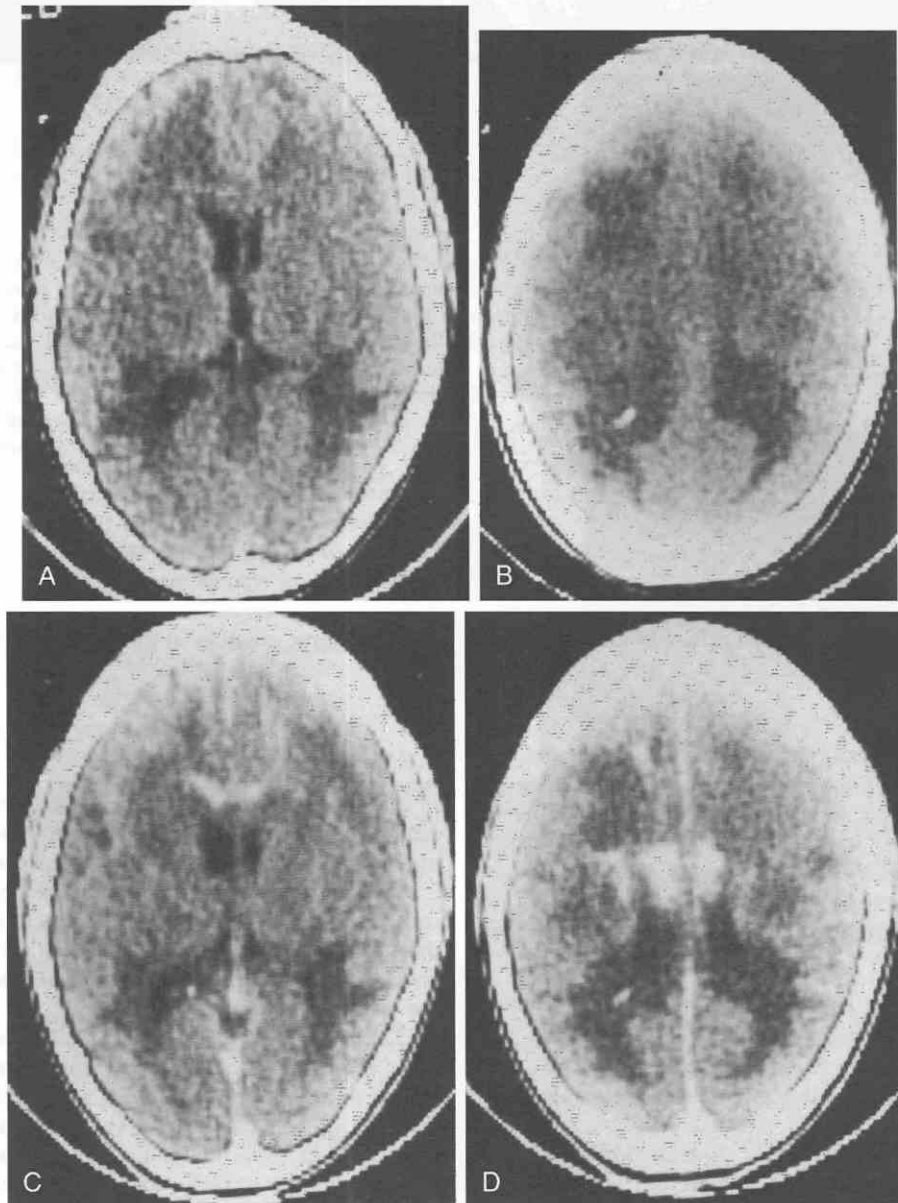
Adrenoleukodystrophy (ALD). The patient is a 13-year-old boy who had behavior problems since age 7 years and who recently experienced seizures. *A* and *B*, Precontrast CT images show white matter lucency surrounding the occipital horns and trigones of the lateral ventricles. Less severe white matter abnormalities are present bilaterally in the frontal lobes. *C* and *D*, Corresponding postcontrast sections demonstrate the peripheral serpiginous enhancement around the frontal lobe lesions and crossing the rostrum of the corpus callosum. Note the lack of contrast enhancement in the older, “burned out” posterior lesions. (Courtesy of Valley Radiologic Associates of San Jose, Calif.)
